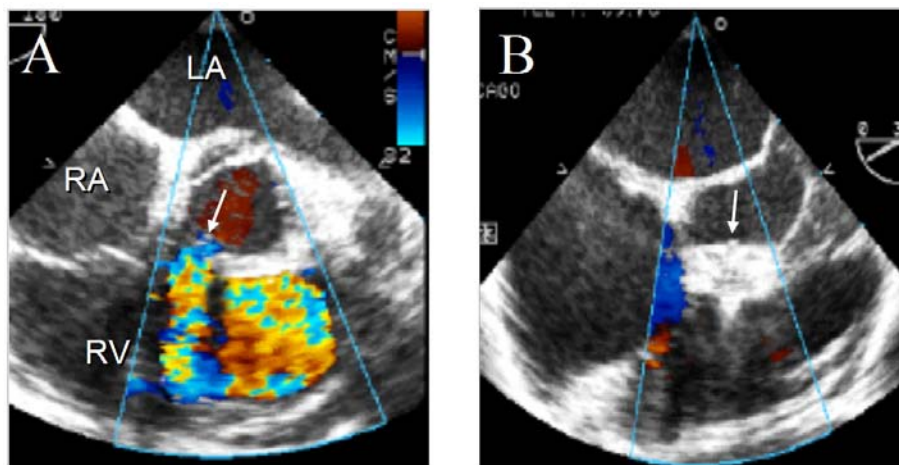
Color Doppler transesophageal echocardiography in short axis view reveals the perimembranous VSD with a left to right shunt (A). Final echocardiography shows no residual shunt (B). LA: left atrium, RA: right atrium, RV: right ventricle.
